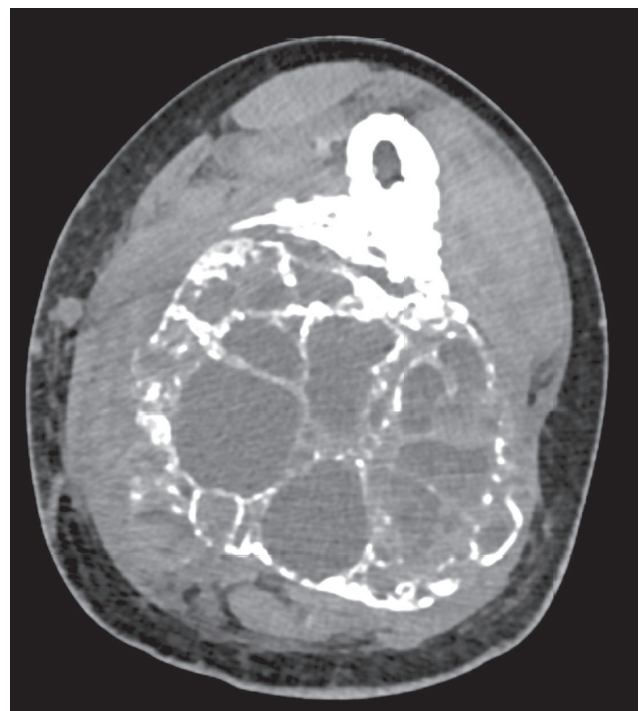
Follow-up CT post-minimally invasive procedures reveals stabilization of mass size and progressive calcification and reduction of cyst volume
